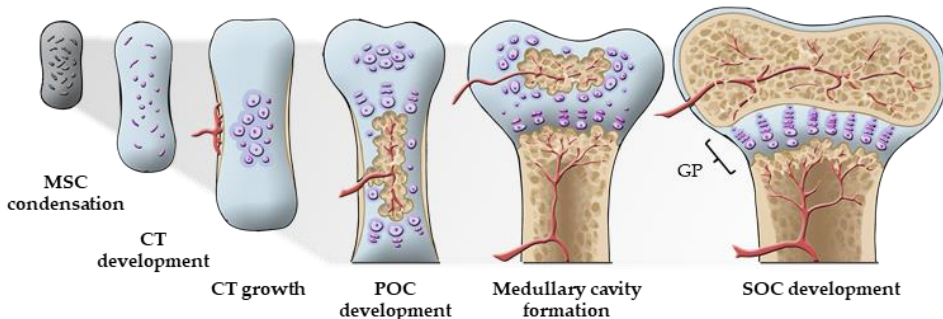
Stages of endochondral ossification. Abbreviations: mesenchymal stem cell (MSC), cartilage template (CT), primary ossification center (POC), secondary ossification center (SOC), growth plate (GP).
